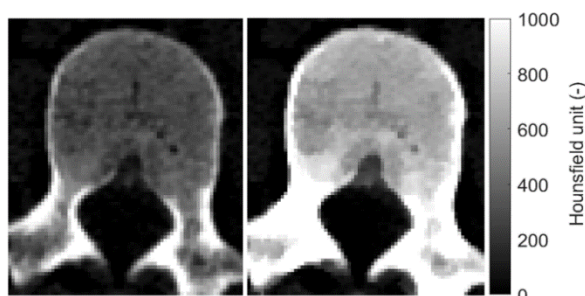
Example of the first lumbar vertebra of a patient without spinal pathologies: on conventional CT (left) and VMI at 40 keV (right).
